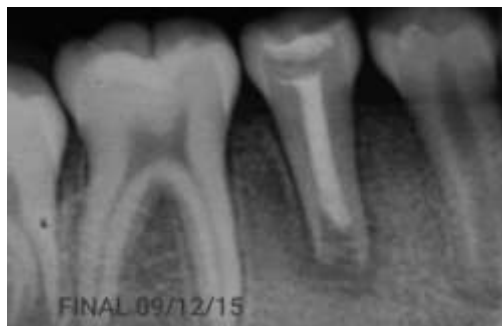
Final radiography
